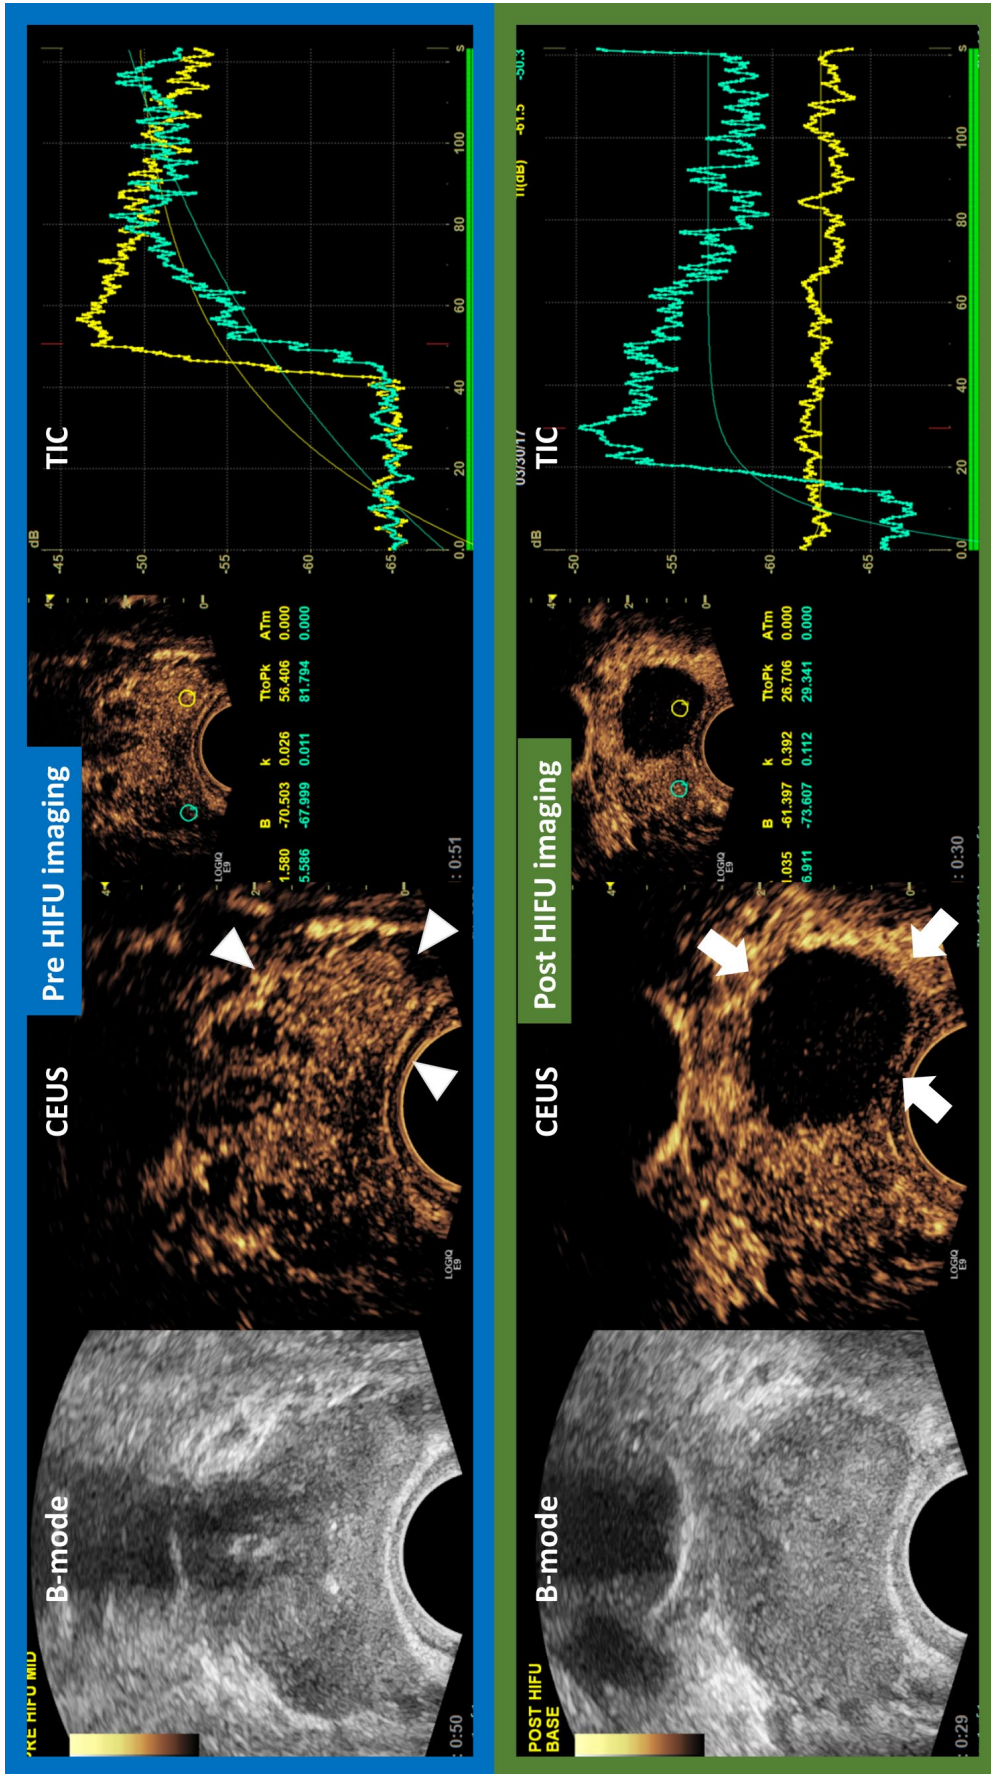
Representative images of pre-/post-HIFU imaging with CEUS. A 62-year-old man with PSA 8.2 ng/ml. Prebiopsy multiparametric MRI revealed PCa suspicious lesion on left side peripheral zone from the base to apex gland level (PIRADS score 5). Systematic 12-core biopsy plus 6-targeted core biopsy revealed GG2 cancer from the left side of the prostate. The patient wished to undergo left hemi-HIFU as a definitive treatment for PCa. Prior to HIFU, CEUS was performed to evaluate vascularity of the bilateral prostate lobes (arrowhead shows contrast enhancement on cancerous area). Time-intensity curves analysis showed higher peak intensity, steeper wash-in slope, and earlier time-to-peak on the left side (yellow circle and yellow graph) of the prostate than those on right side (green circle and green graph). Immediately after HIFU, a second CEUS evaluation was performed to confirm the ablated area (arrow). While the treated side lobe successfully lost vascularity, the contralateral side maintained vascularity. At this point, the procedure was terminated. Postoperatively, PSA dropped to 0.26 ng/ml, follow-up imaging [mpMRI, B-mode TRUS, CDUS, and CEUS] did not detect PCa recurrent suspicious lesion. One year after HIFU, follow-up systematic biopsy confirmed no cancer on both treated and untreated side of the prostate.
